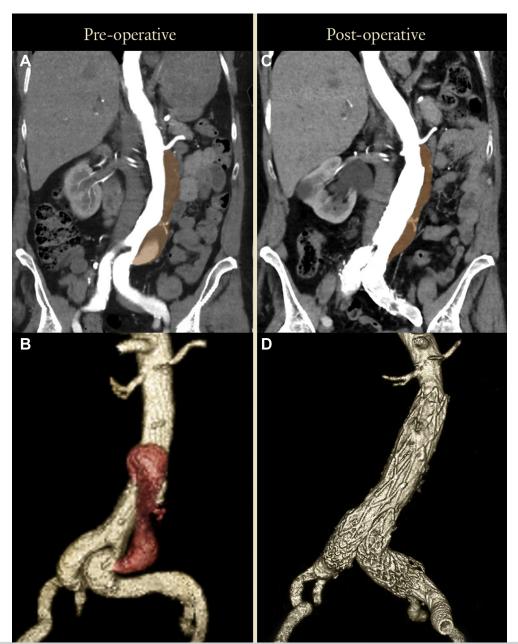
A, Preoperative computed tomography scan with extent of false lumen to zone 8 proximally and zone 10 distally highlighted. B, Three-dimensional reconstruction of preoperative computerized tomography, demonstrating extravasation of contrast from the true lumen (*white*) into the false lumen (*red*) through fenestrations in zones 9 and 10. C, Postoperative computed tomography scan showing significant shrinkage of the false lumen, highlighted. D, Postoperative three-dimensional reconstruction demonstrating cessation of false lumen flow.
